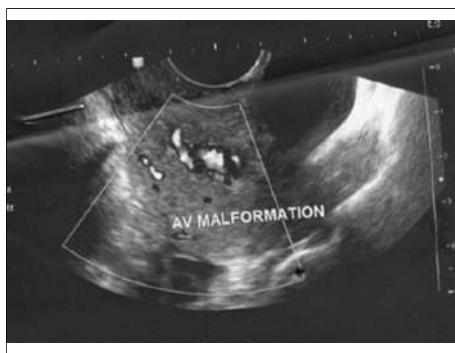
Colored Doppler ultrasound imaging feature of uterine arteriovenous malformation.
